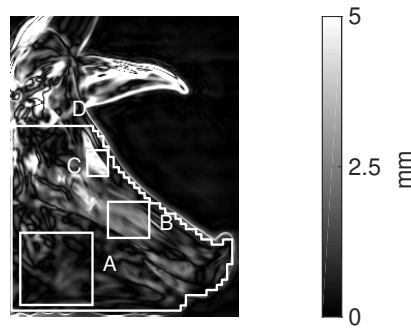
Absolute error between the WEPL predicted using the calibration curve of our TPS and the WEPL obtained via a sparse deconvolution of the proton radiography data.
